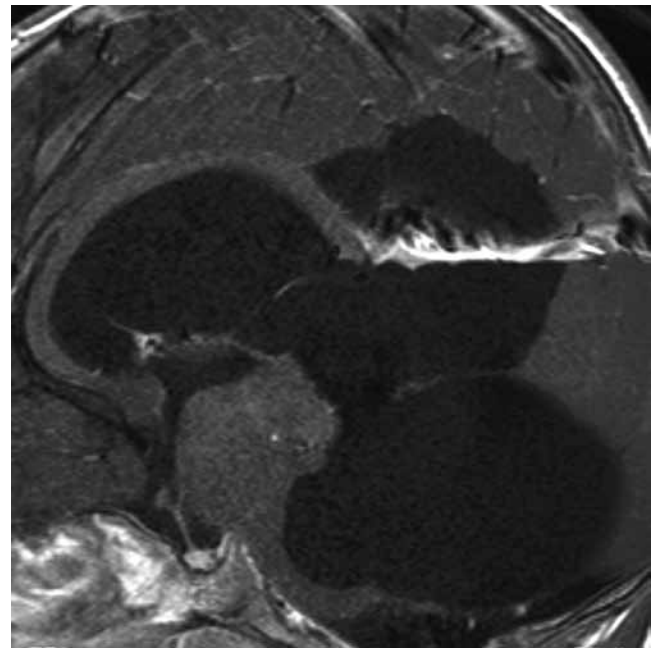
Sagittal postcontrast T1-weighted MR image. No enhancement is seen; the lesion is isointense to gray matter tissue.
